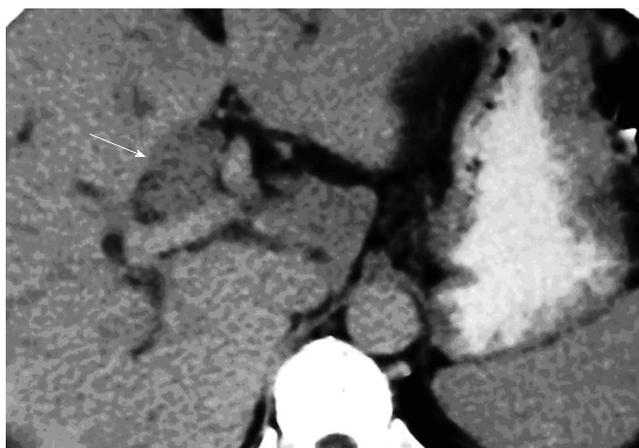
Axial contrast enhanced computed tomography scan in venous phase of papillary type of hilar cholangiocarcinoma showing minimally enhancing intraductal polypoidal lesion (arrow) causing distension of the duct.
